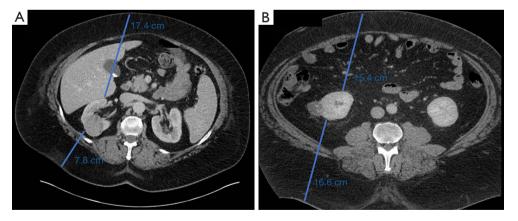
Representative patient images. Preoperative computed tomography images of a 4.1-cm tumor in a female with a BMI of 44.8 kg/m² (A) and a 2.8-cm tumor in a male with a BMI of 54.3 kg/m² (B). Anterior and posterior skin-to-kidney distances are measured. BMI, body mass index.
